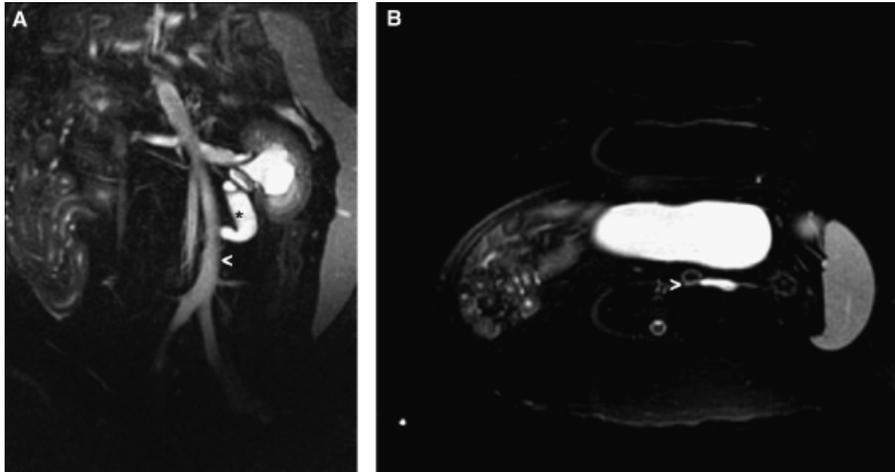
(A) Static-fluid T2-weighted TSE fat-saturated dorsal image (TR = 5000 ms, TE = 97 ms). The marked pyelectasis and dilation of the proximal part of the left ureter are clearly seen (black star). The left proximal ureter is characterized by a medial and dorsal deviation and the dilation ends abruptly in the area of a large, left sided curving abdominal vessel suspected to be a malpositioned caudal vena cava (white arrowhead). Right is to the left and cranial is to the top. (B) In the transverse plane, the end of the dilated part of the left ureter is seen dorsal to this large abdominal vessel (arrowhead). The left ureter was barely visible distal to the occlusion. Right is to the left and ventral is to the top.
